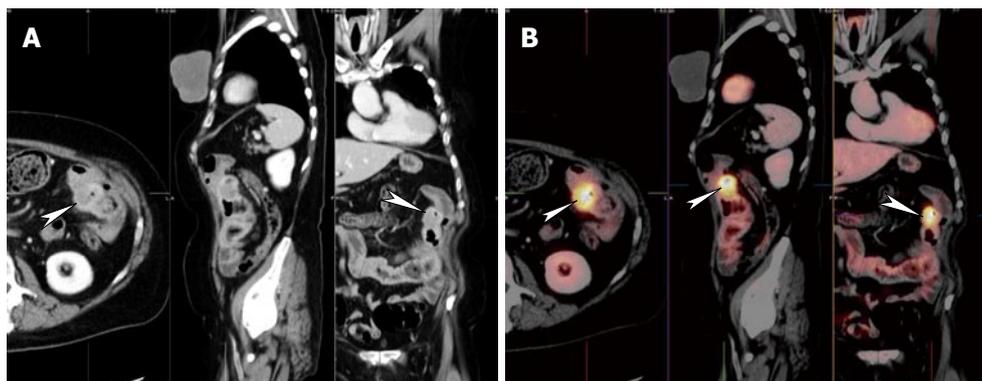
Thirty-nine years old female with prior sigmoid colectomy for cancer, presented with rising CA-125. A: Axial, coronal and sagittal images of CT raised concern for possible mass adjacent to the splenic flexure (arrowheads); B: Fused images of PET and CT showed hypermetabolic focus (arrowheads) in the mesocolon adjacent to splenic flexure, indicating recurrent tumor. No other sites of tumor were found. While PET is sensitive for recurrent disease it has poor spatial resolution and it would have been difficult to determine if the recurrence was in the colon, mesentery or adjacent spleen. Fusion of PET and CT images allowed accurate anatomical localization.
